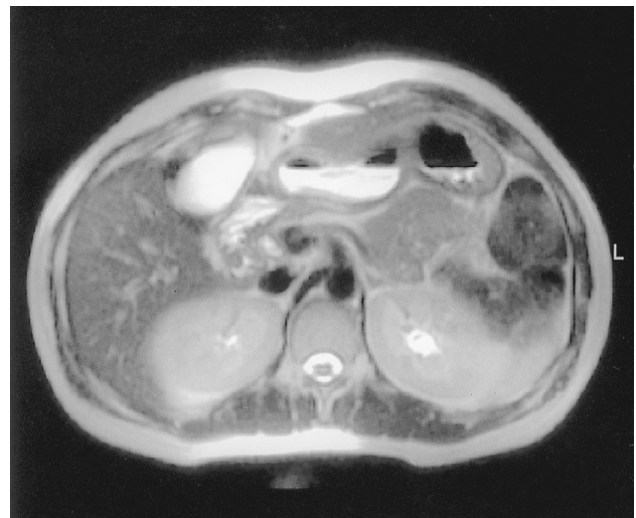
Abdominal magnetic resonance imaging (MRI) shows a pancreas head only, with nonvisualization of the body and tail.
